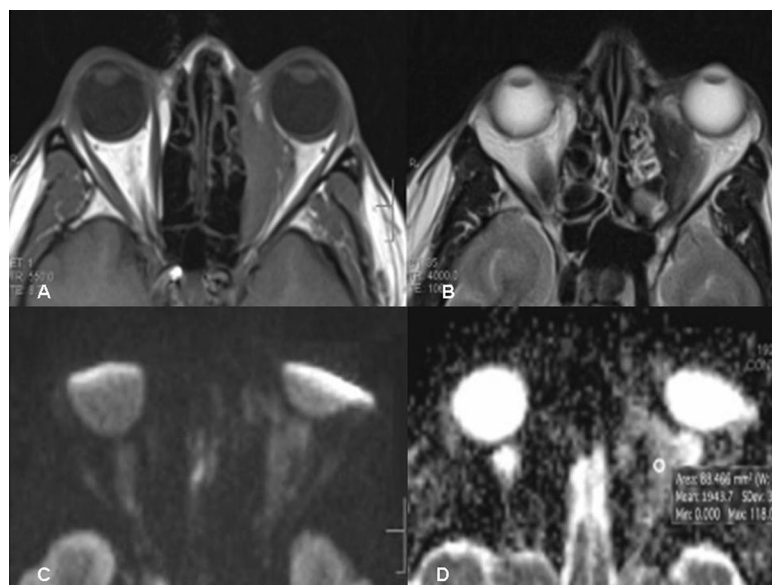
A 13-year-old male with acute pan-sinusitis; presented with right-sided dull aching orbital pain, mild proptosis and limited orbital gaze. Axial T1 image (A) shows diffusely enlarged right superior and medial recti with mild haziness of the right intraconal retro bulbar fat. Axial T2 image (B) shows diffuse enlargement of the right superior and medial recti muscles with mild hyperintense signal. No diffusion weighted restriction seen on DWI (b_{500}) image (C) and ADC (D). The ADC value is $1.34 \times 10^{-3} \text{ mm}^2/\text{sec}$. Right-sided orbital inflammatory pseudotumor, Myositic type. Therapeutic trial with corticosteroids was done and the patient relieved after 5 weeks
